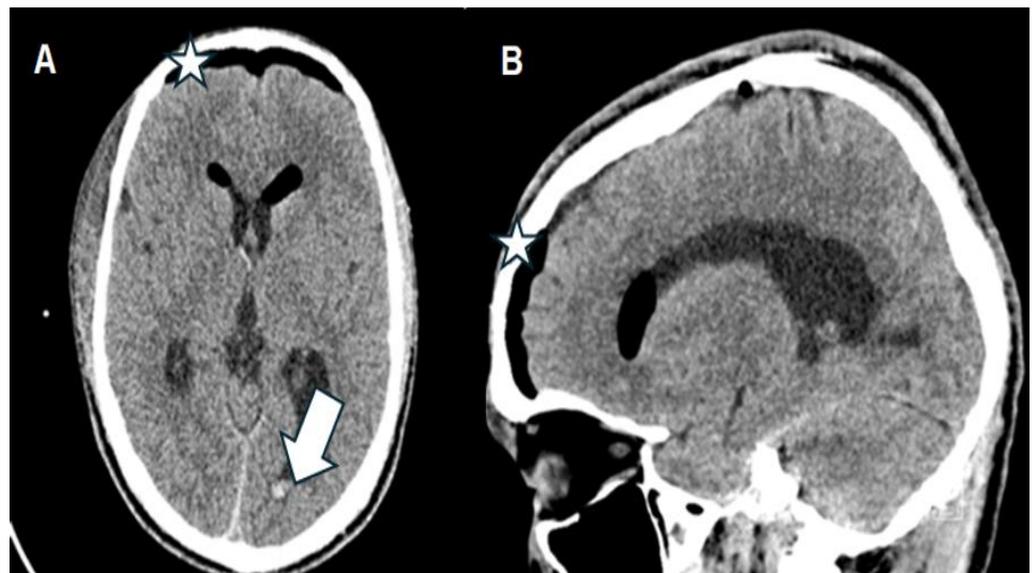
A and B Axial and sagittal non contrast CT of the brain show frontal pneumocephalus (white stars) with air pockets within the frontal horns of the lateral ventricles. Minimal intraventricular haemorrhage is seen within the occipital horn of the left lateral ventricle (white arrow).
